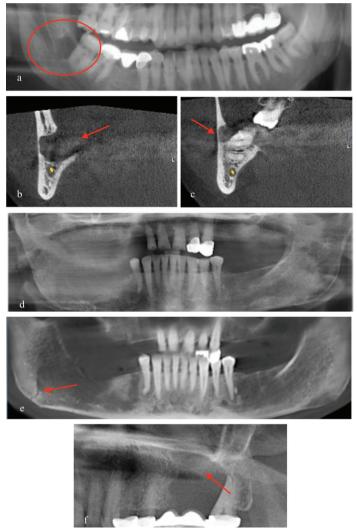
Panoramic and CBCT images of the patients with mucoepidermoid carcinoma, small cell lung cancer metastasis and clear cell adenocarcinoma. Panoramic radiograph (a) and CBCT coronal sections (b,c) images of a patient diagnosed with mucoepidermoid carcinoma. Clear borders of the radiolucent lesion located distal to the second molar. CBCT reformat panoramic radiography image (e) of a patient with small cell lung cancer metastasis shows a fracture in the right mandible angulus (red arrow) that is not observed on the panoramic radiograph (d). Cropped panoramic radiograph image of the patient with clear cell adenocarcinoma (f).
